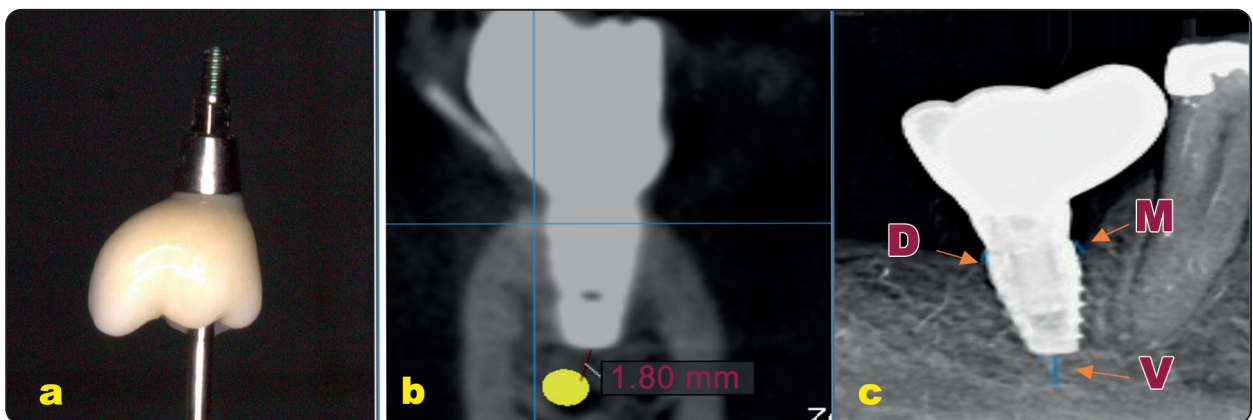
Showing (a) Screw retained prosthesis with Ti-base abutment (b) 3 months post-operative CBCT showing relation of implant to vital structure and bone implant relation. (c) periapical radiograph showing (M) distance between implant platform and first bone contact mesially (D) distance between implant platform and first bone contact distally (V) distance between implant apex and inferior alveolar canal.
